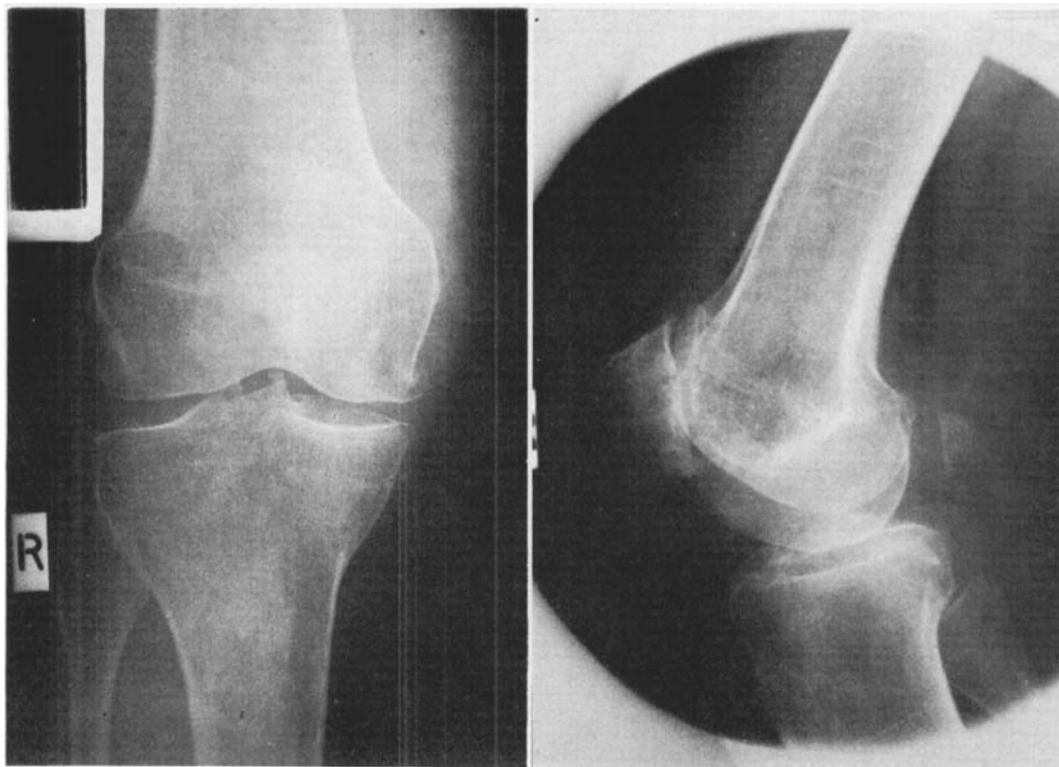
a. Case V.A. Preoperative radiographs 1964. Bare bone present in all compartments. Patellectomy done.
